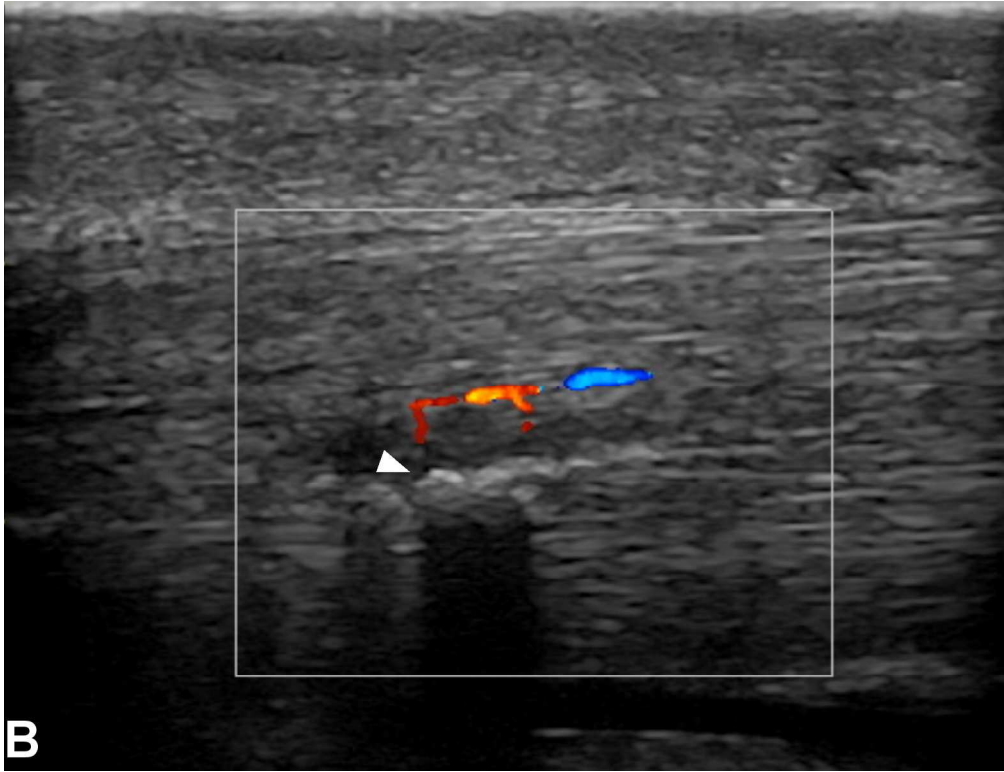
Transverse (A) and longitudinal (B) ultrasound images from deep digital flexor tendon case 7 showing Doppler signal associated with poorly defined focal mineralisation (arrowheads). This mineralisation was associated with lameness based on a positive response to intrathecal analgesia.
